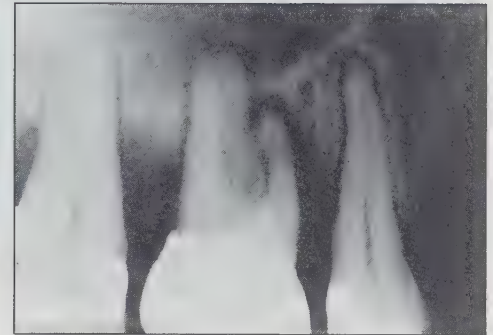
Radiograph early in treatment with fixed appliances showing extraction of first premolar. Note calculus on roots, severely widened POL spaces, and early crestal bone loss on molar.
